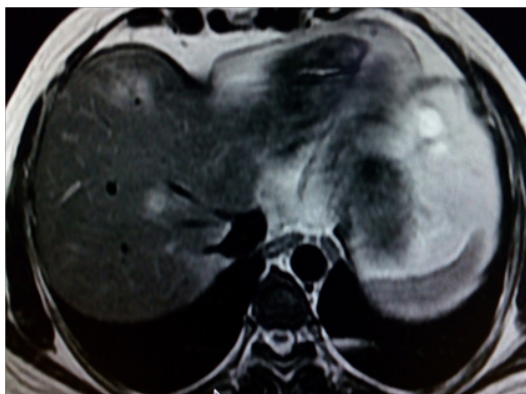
MRI showing multiple lesions.
